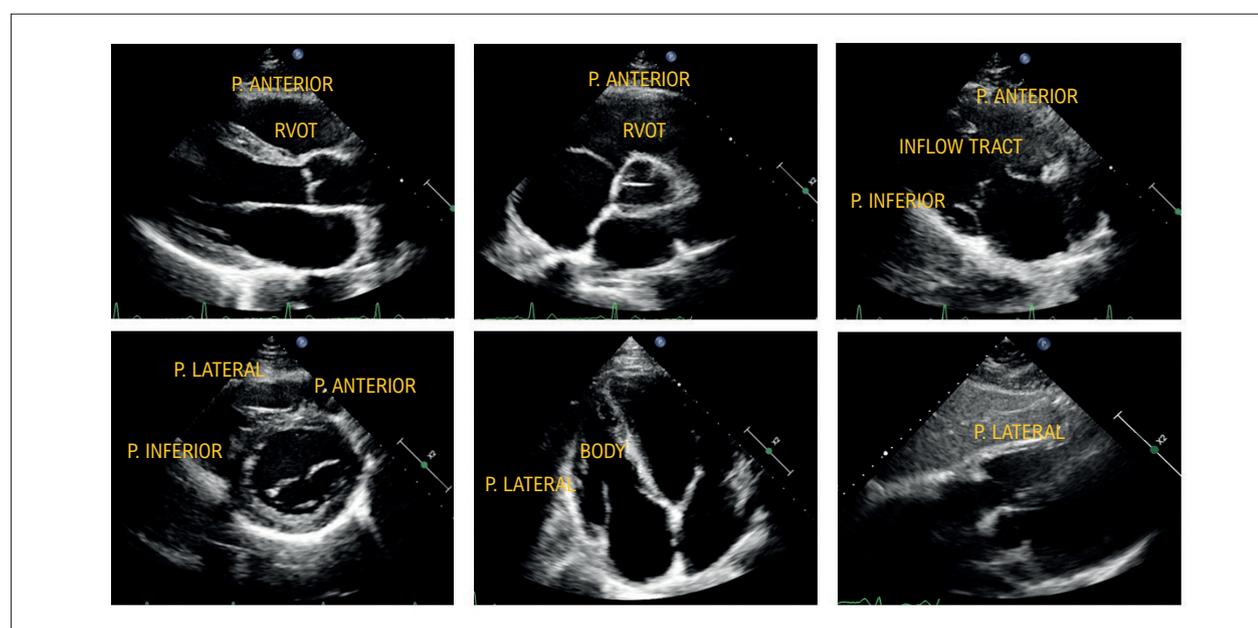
View of the RV and its walls in the parasternal, apical 4-chamber windows focused on the RV and subcostal. RV: right ventricle; RVOT: right ventricular outflow tract; P: wall.
